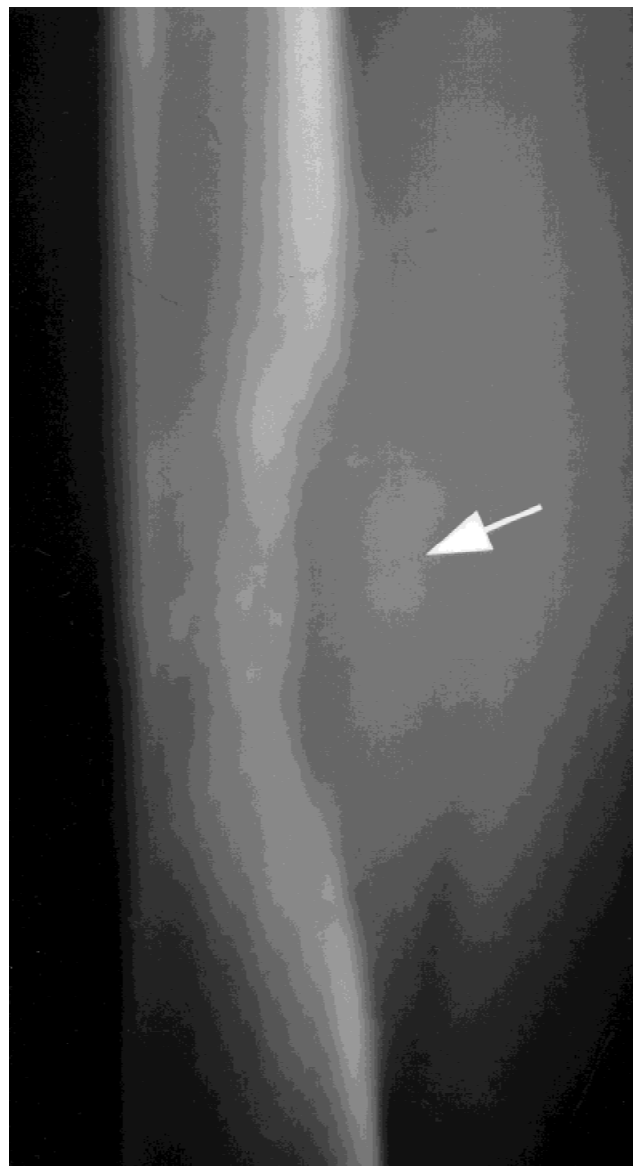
Fifty-eight-year-old man with previously diagnosed pulmonary adenocarcinoma who developed thigh pain. Plain films of the femur revealed extensive cortical destruction with some extension into the medullary cavity (arrow).
